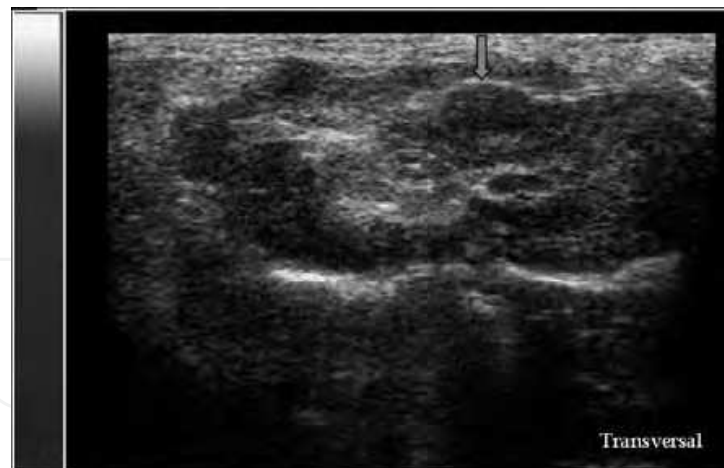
Transversal sonogram shows a cirrhotic liver with an isoechoic regenerative nodule (arrow).
